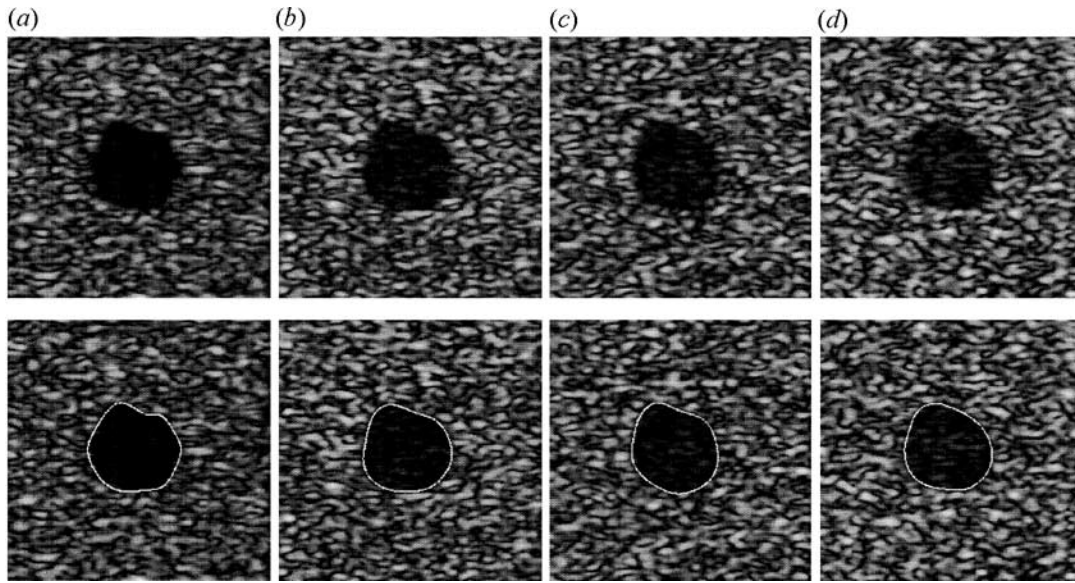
Top: synthetic ultrasound images with the ultrasound texture model developed in Meunier and Bertrand [31] and for different ratios of noise level (the backscattering ratio between the two regions is respectively: 10, 7, 6 and 5). Bottom: segmentations obtained with our method. (a) Rate of correct classification: 95.98%; (b) rate of correct classification: 95.12%; (c) rate of correct classification: 95.12% (d) rate of correct classification: 93.65%.
